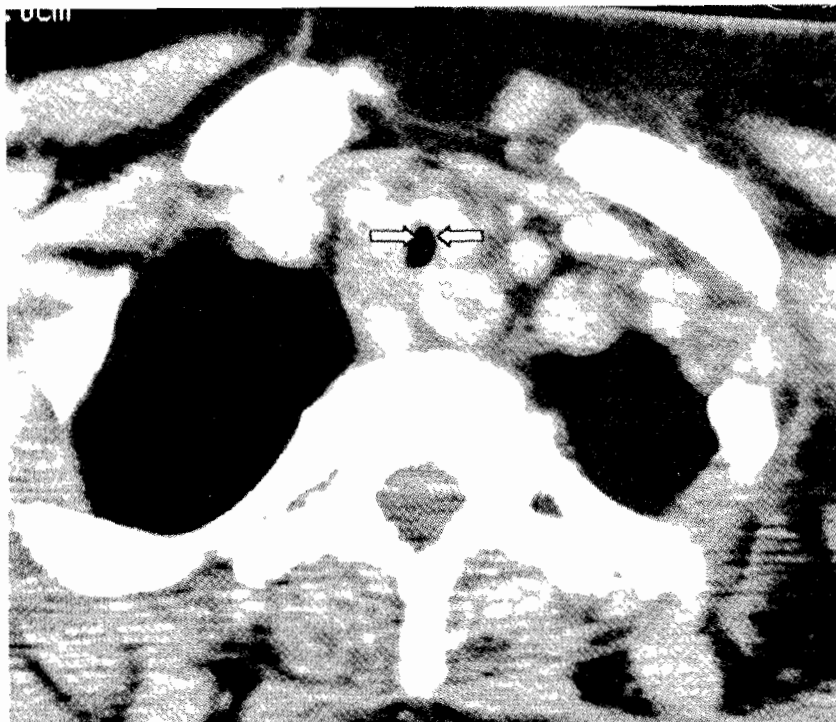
Plain CT scan of the neck in a 20-year old female with acquired tracheal stenosis (Case # 3) due to the development of granulation tissue (white arrow) in the trachea.
